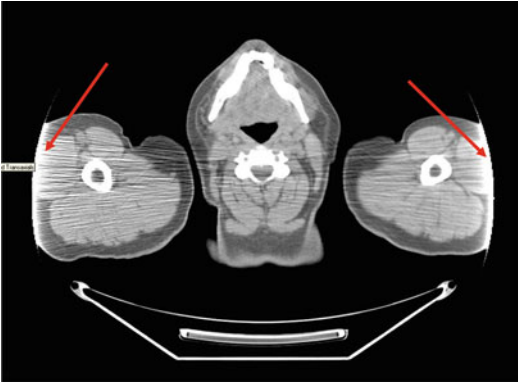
A CT scan of a 145-kg man imaged with arms up. Arrows show truncation artifacts
